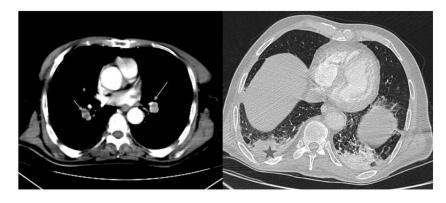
The patient benefited from a thoraco-abdomino-pelvic CT scan which objectified the presence of a bilateral pulmonary embolism, proximal on the left, complicated by bilateral LI pulmonary infarction foci.
